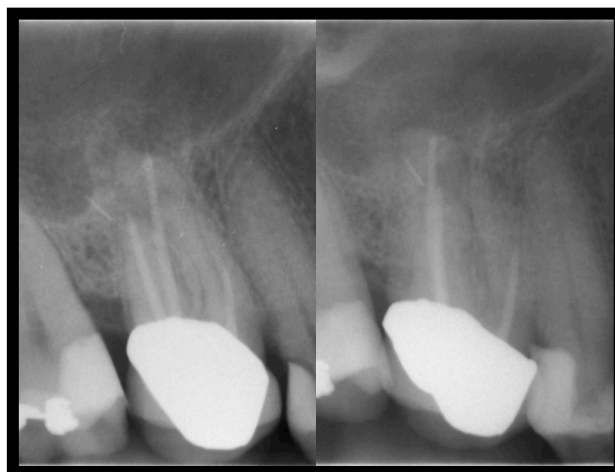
Radiographic history. Left: May 2009; Right: Oct. 2011
